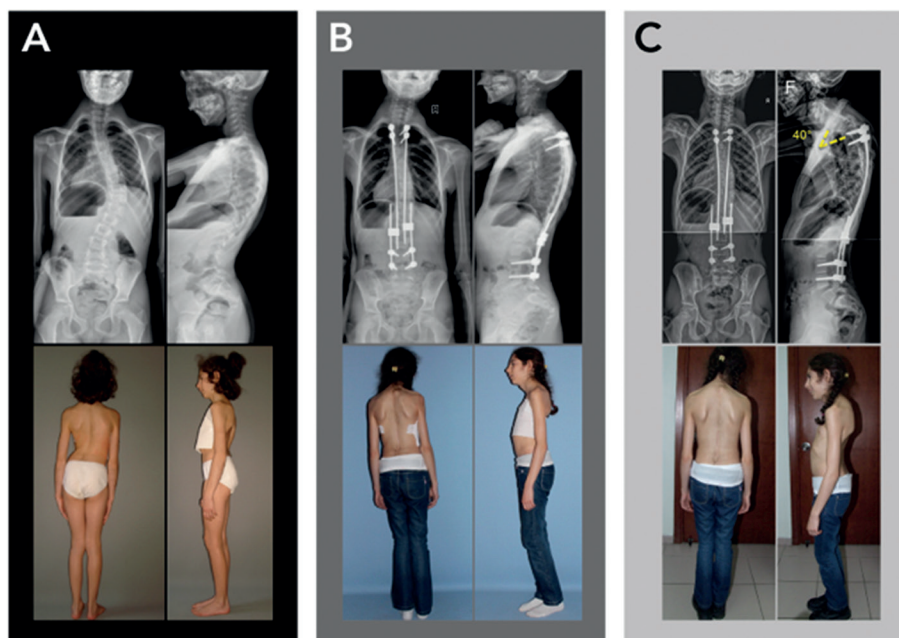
EOS with unidentified syndromic reason (in a 9-year-old female). The follow-up period was 24 months, three lengthenings performed during this period: (A) preoperative AP-lateral x-ray (50° major scoliosis and 40° kyphosis) and clinical pictures, (B) 12 month-follow-up postoperative GR, and (C) the latest follow-up PJK (40°) seen after GR distraction (29° major scoliosis and 39° kyphosis).
